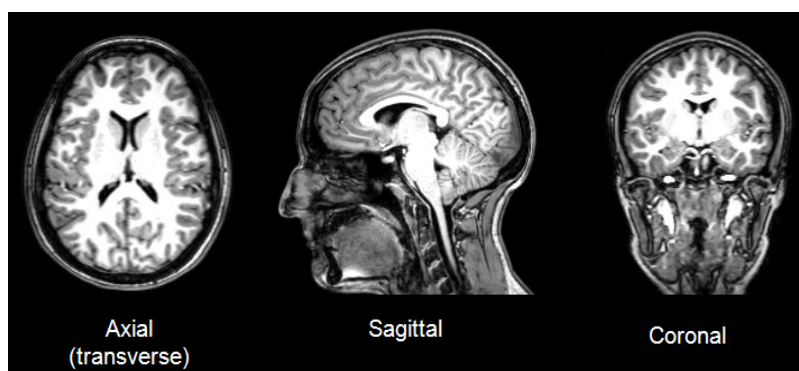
Cross section views of a T1 weighted image to show the different planes in MRI.
